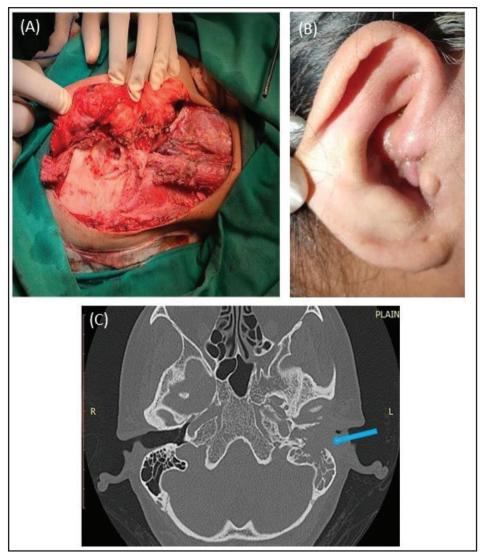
Images of patients with temporal bone squamous cell carcinoma. (A) Intra-operative image of right subtotal temporal bone resection (B) External auditory mass (C) Computed tomography imaging at the base of skull in bone window, showing a mass in the external auditory canal of the left ear (blue arrow) that is invading into the left mastoid air cells.
